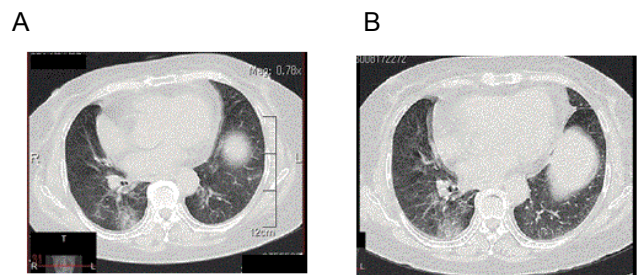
Chest CT scan image showing diffuse GGO in the right lower lobe on days 1 (A) and 3 (B) of the hospital admission.
